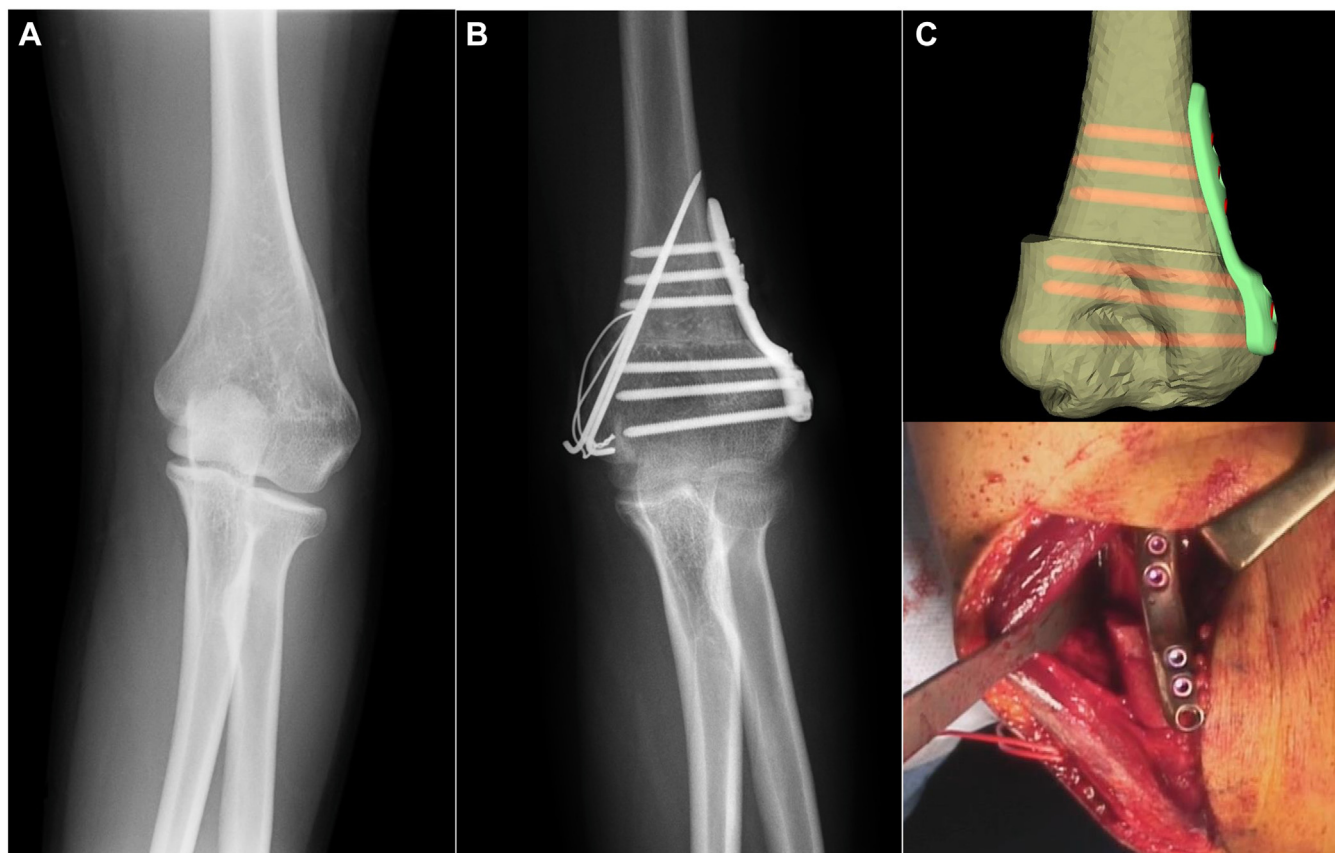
(A) Preoperative (B) and postoperative anteroposterior plain radiographs. (C) The upper part is the computer-aided design of the patient-matched plate, whereas the lower part is the intraoperative photograph of the patient-matched plate.
